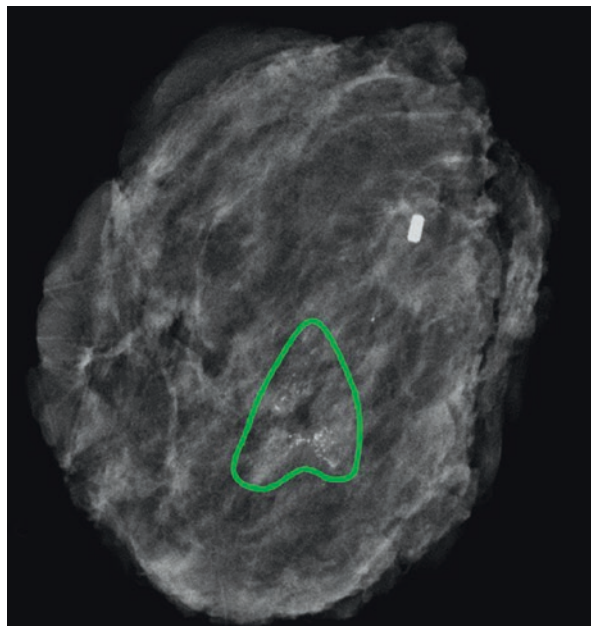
Surgical sample X-ray showing the presence of the microcalcification cluster and the clip, which was left there during the performing of the stereotactic-guided core biopsy
